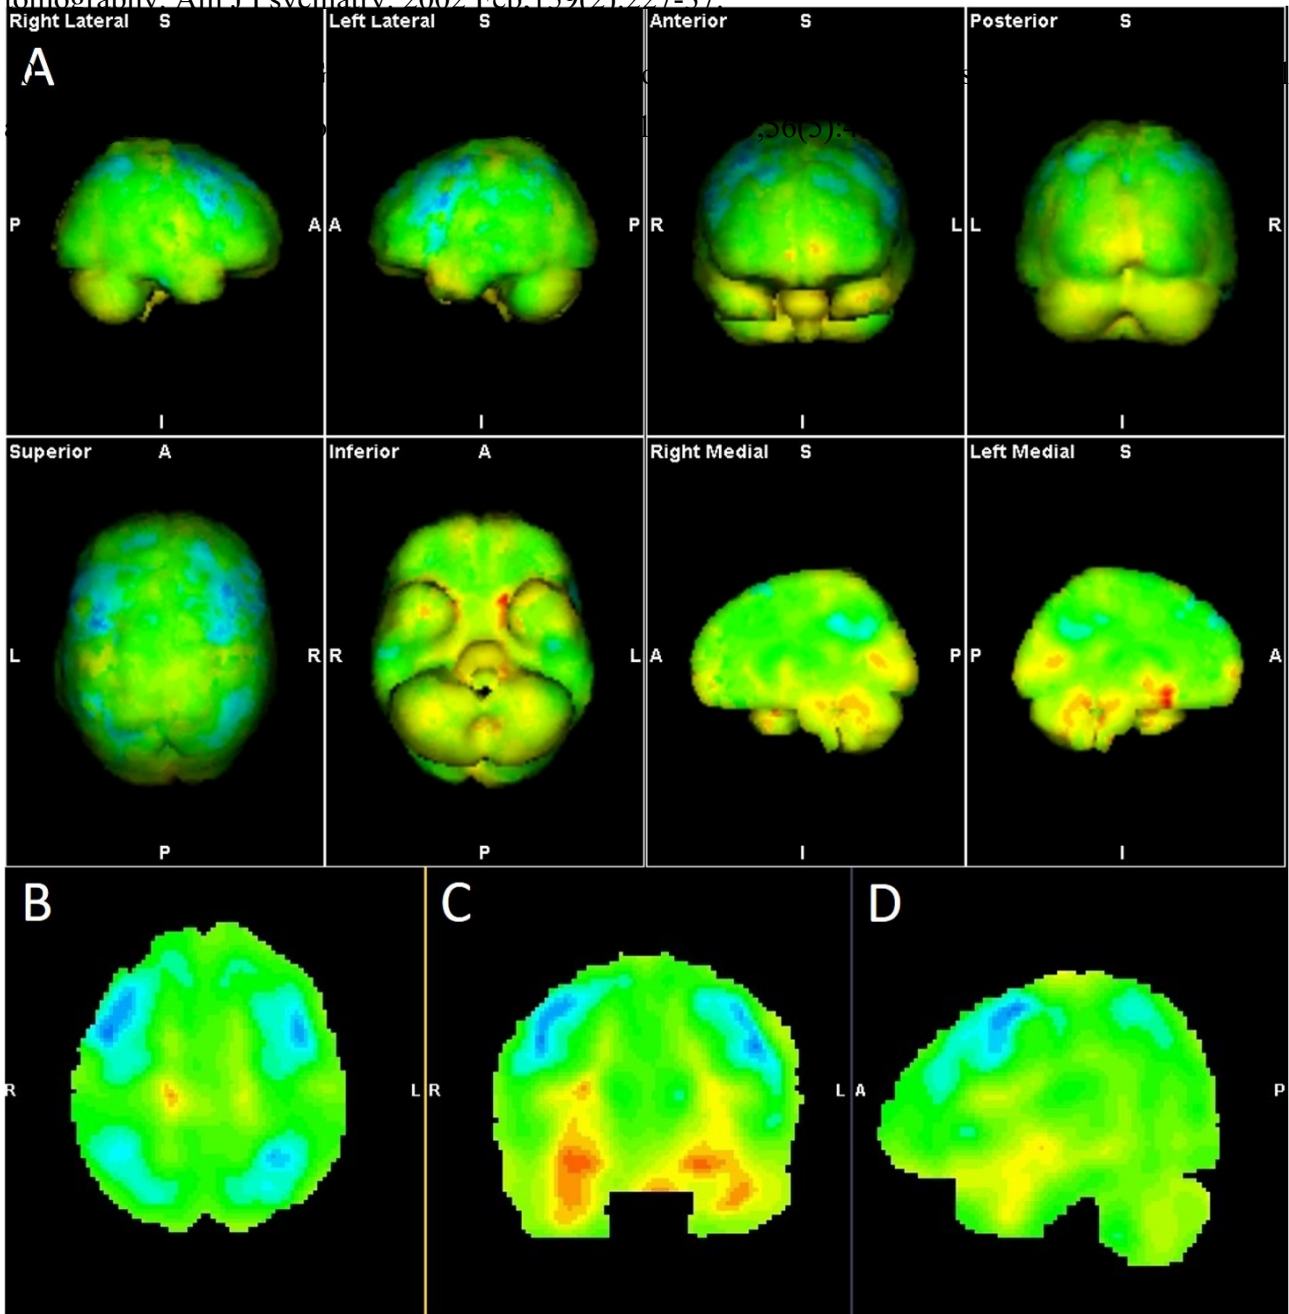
Brain ^{18}F -FDG PET/CT. A (series): multiple views of global FDG uptake parameterized with mean SUV difference from normal subject (Scenium analysis). B, C, D: respectively axial, coronal and sagittal view of PET scan where a bilateral lower FDG uptake is evident in MFG
